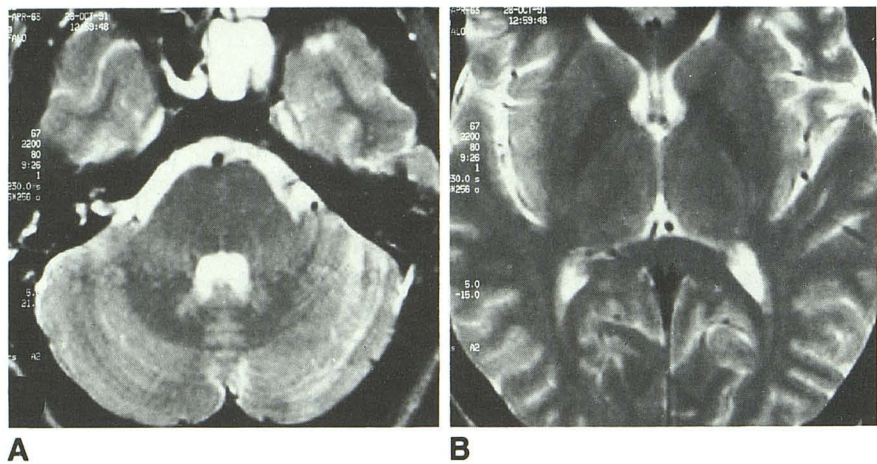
Spin-echo T2-weighted axial follow-up (2200/80/1) after therapy: resolution of the abnormal signal intensities.
